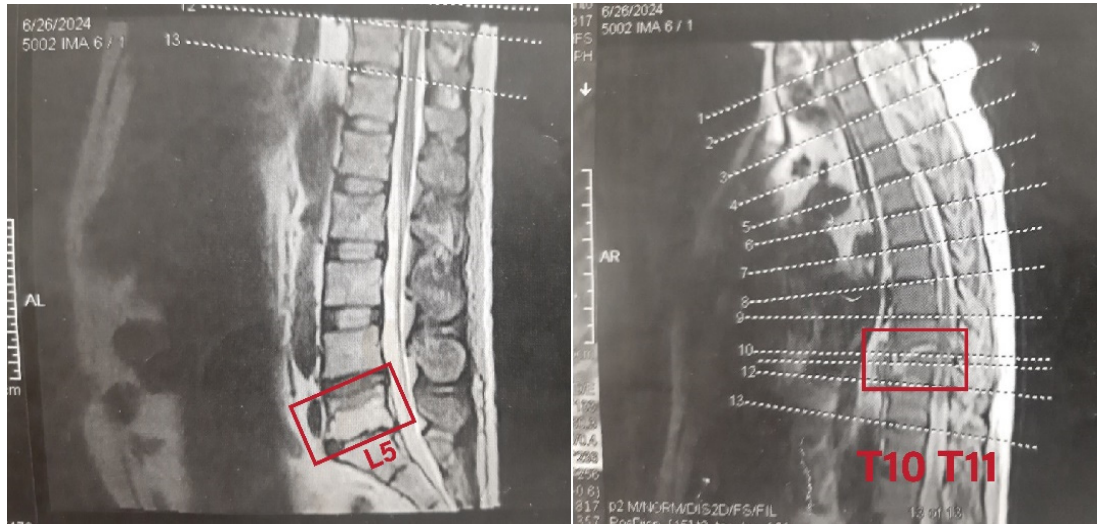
(T10, T11 and L5 fracture: Spinal MRI revealed the destruction of T10, T11 and L5 vertebral bodies.)
